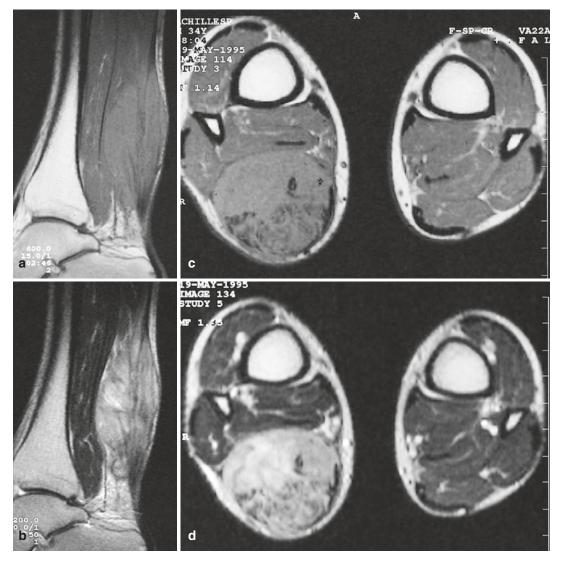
Clear cell sarcoma of the left calf in a 34-year-old man. (\mathbf{a} , \mathbf{c}) Sagittal and axial spin-echo T1-weighted MR images. (\mathbf{b} , \mathbf{d}) Sagittal and axial turbo spin-echo T2-weighted images. The presence of a large, fusiform mass extending along the Achilles tendon. On the sagittal T1-weighted MR image, (\mathbf{a}) the lesion appears homogeneous. On the axial view, numerous hypointense, curvilinear dashes are observed within the posterior portion of the mass. The bulk of the mass is nearly homogeneous and is slightly hyperintense to
